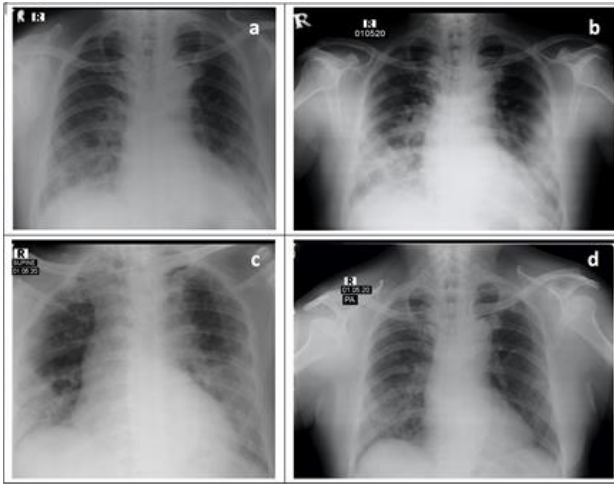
Chest radiographs showed progression of bilateral infiltrates of the lung, and improvements of chest radiographs on the follow-up. a: March 14 (hospital day 1 / illness day 5); b: March 18 (hospital day 4 / illness day 8); c: March 28 (hospital day 10 / illness day 14); d: May 5 (hospital day 17 / illness day 21).
